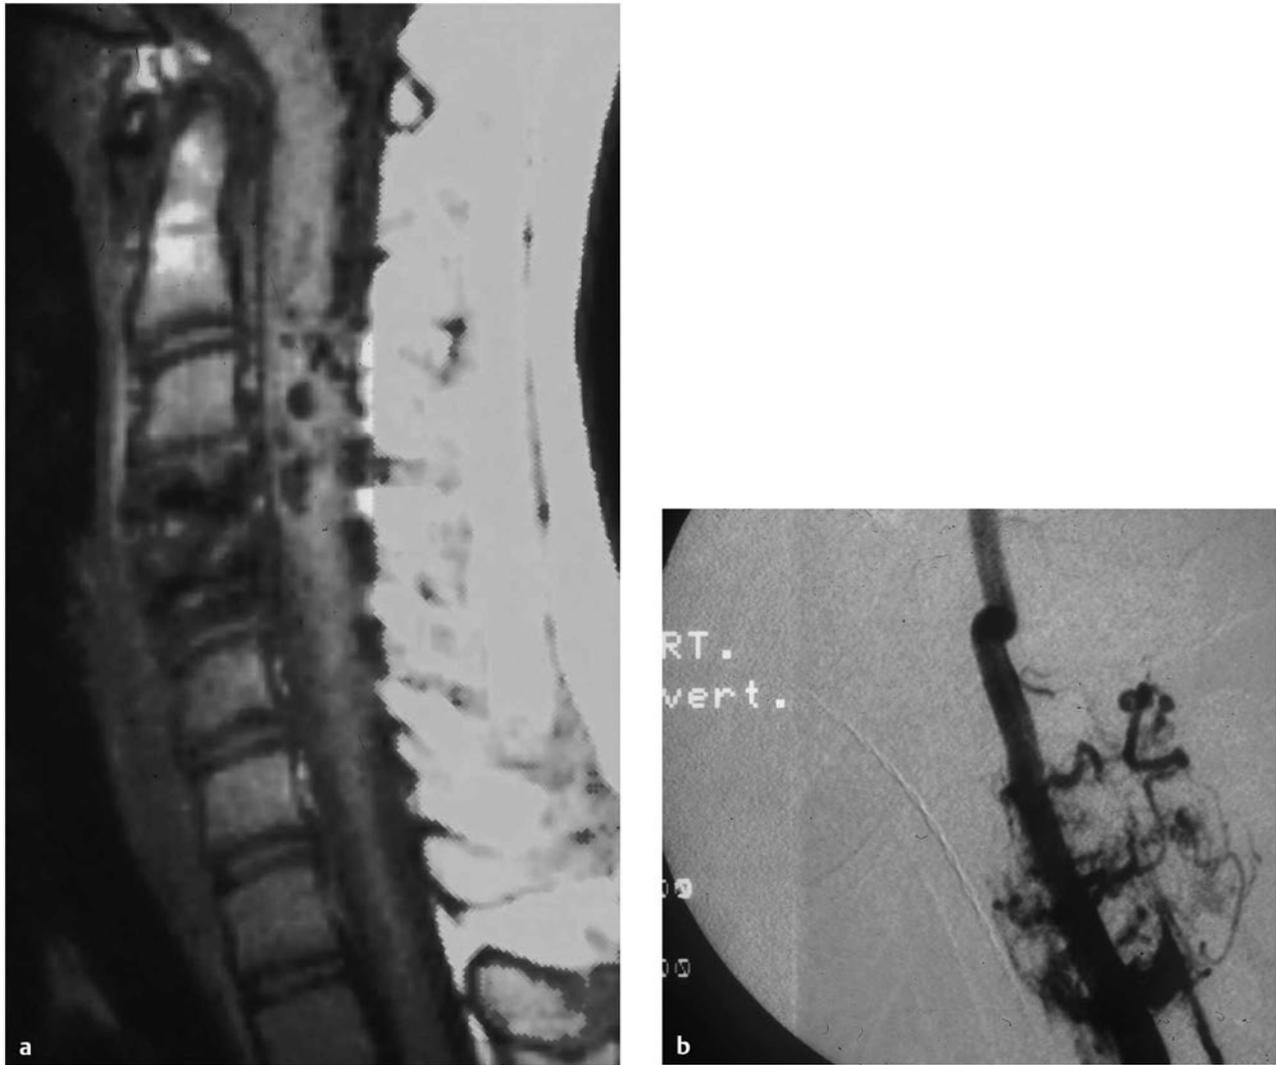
(a) Magnetic resonance image and (b) angiogram showing a metamerically spinal arteriovenous malformation.
